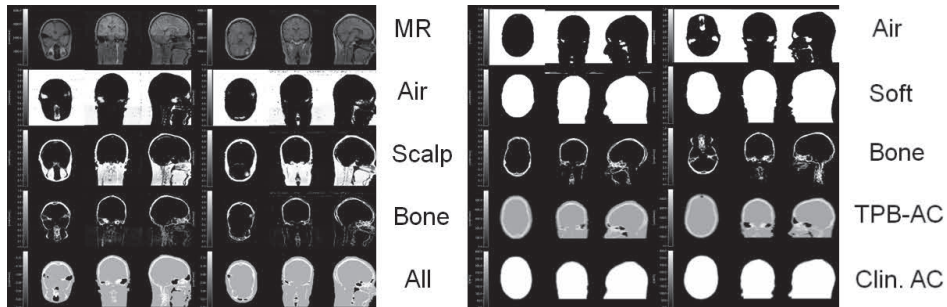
Patient MRI images, tissue probability masks before and after processing and the final TPB-AC attenuation map compared to the clinical MR-based attenuation map. Clin. AC denotes vendor-supplied MRAC. Modified from Study II. © 2016 IEEE
